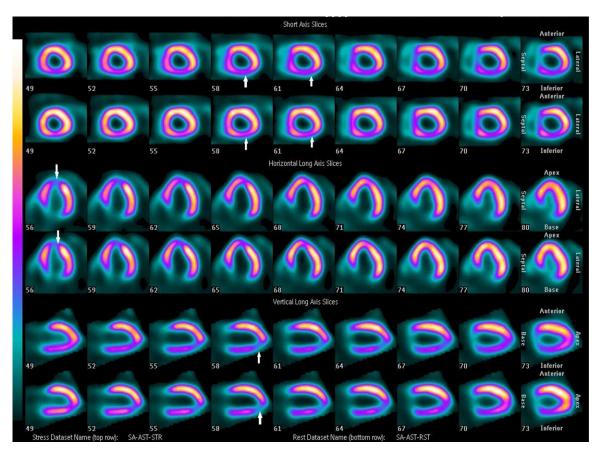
Single-photon emission-computed tomography (SPECT) in short axis, horizontal long axis, and vertical long axis standard views. Top row: Stress images clearly show the left ventricular myocardial imaging. Part of the left ventricular inferior wall near the apex can be seen with defects. Bottom row: The remaining images show that the above areas are not filled, compared with the stress images.
